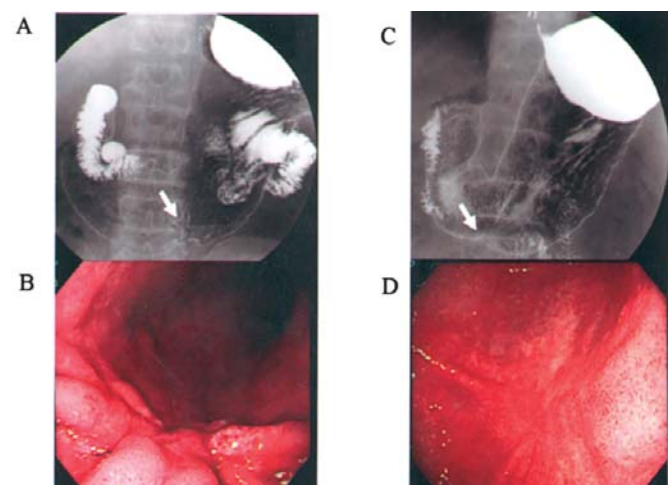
Roentgenological and endoscopic findings demonstrated that the depression in the greater curvature was accompanied by fold convergence before chemotherapy (A and B). After chemotherapy the depressed lesion was flattened (C and D).
